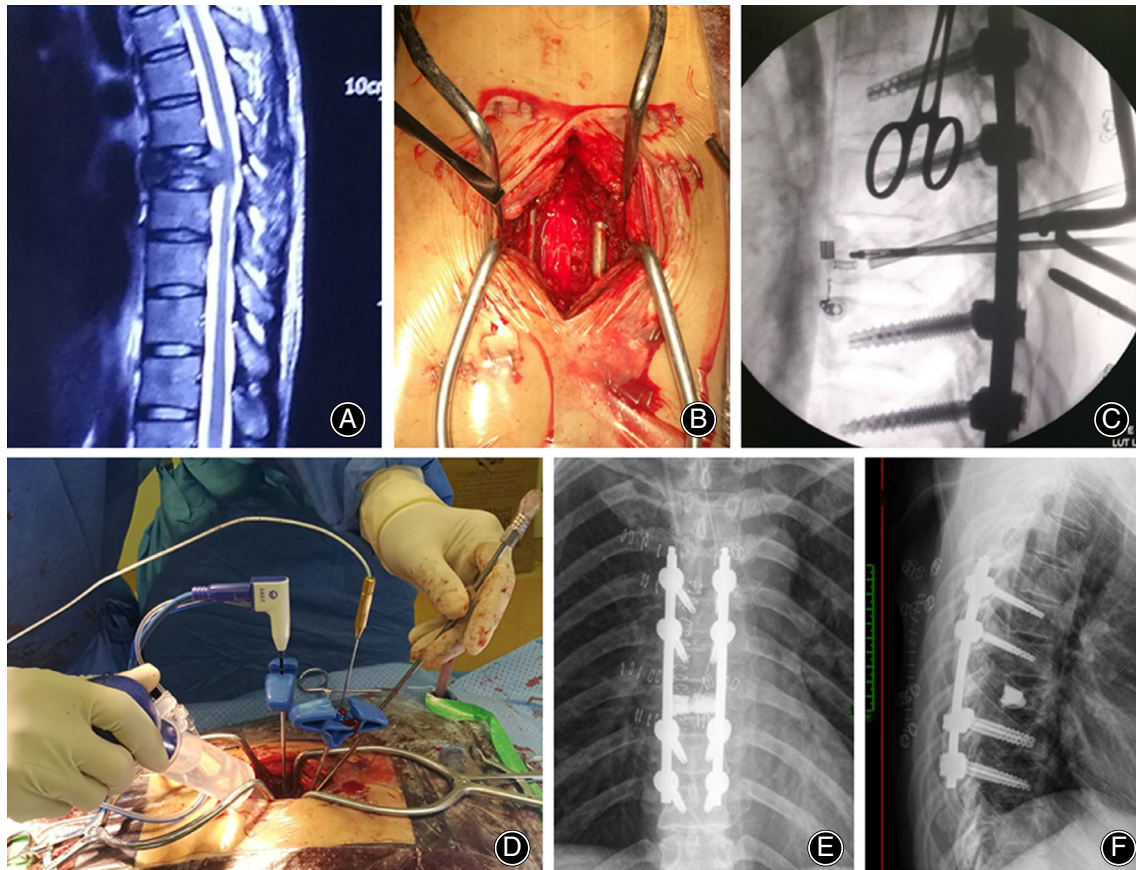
Preoperative sagittal magnetic resonance images (a) show metastasis of T8 from lung cancer with neurologic compression in a 46-year-old man. After pedicle screw fixation, the spinal process and lamina were removed to expose the Dural sac involved (b). The precise position of microwave needle was monitored by intraoperative fluoroscopy (c). Microwave ablation needle and thermometer were inserted into the vertebral metastases through the pedicle (d). Postoperative frontal (e) and lateral (f) X-rays were taken
